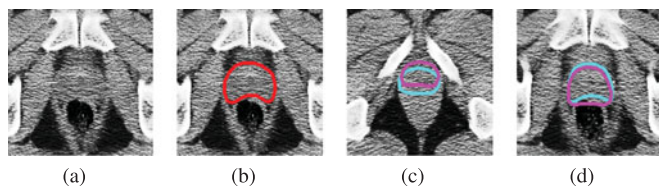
Challenges in prostate CT segmentation. (a, b) Low contrast in CT image (without and with manual segmentation); (c) Large prostate motion; (d) large shape change, relative to the bones, even after bone-based alignment for the two CT images.
